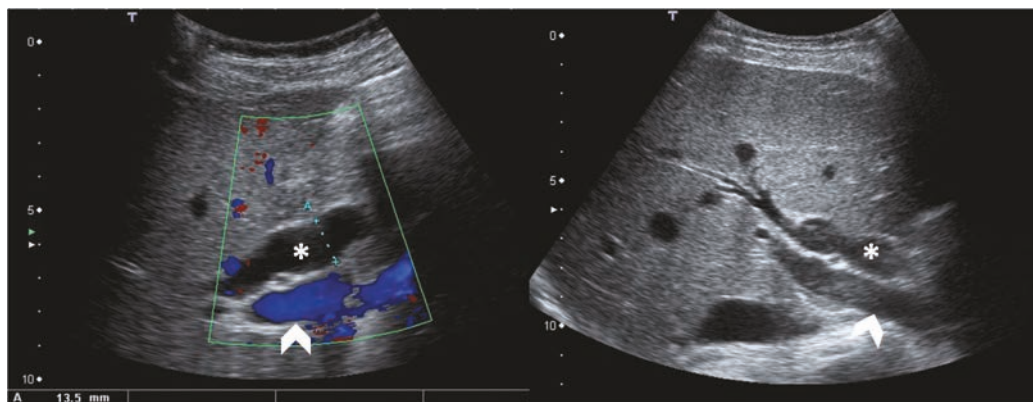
Ultrasound of the biliary system shows common bile duct dilatation (*) with the normal adjacent portal vein (arrowhead).
